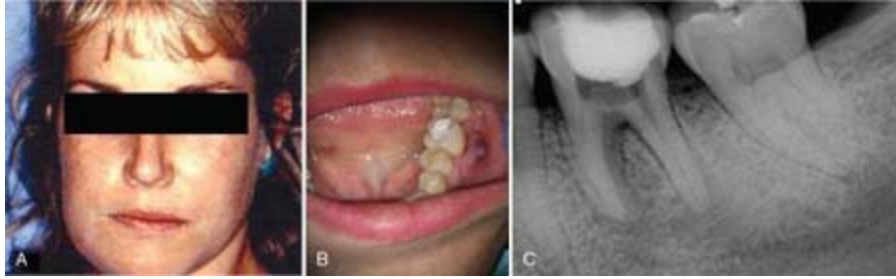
A, Buccal space swelling of the left side of the patient's face. Note the asymmetry of the left side of the face. B, Intraoral view of another patient shows swelling present in the left posterior mucobuccal fold. C, This buccal space infection was associated with periradicular disease from the mandibular left first molar. Note on the radiograph the periradicular radiolucency and incomplete endodontic treatment.
